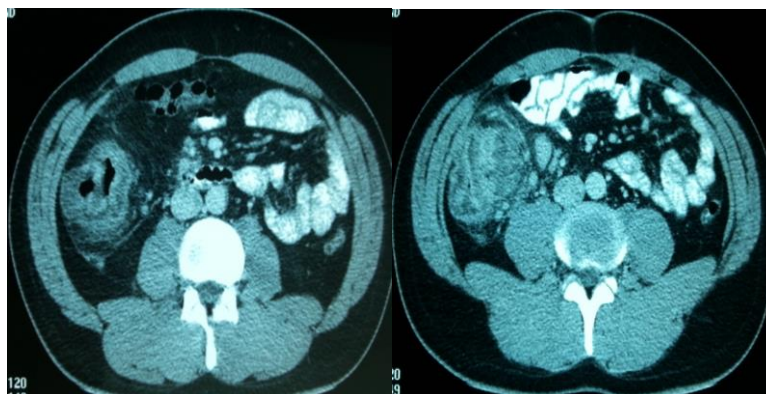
Computed tomographies showing an heterogenous mass in the cecum.
